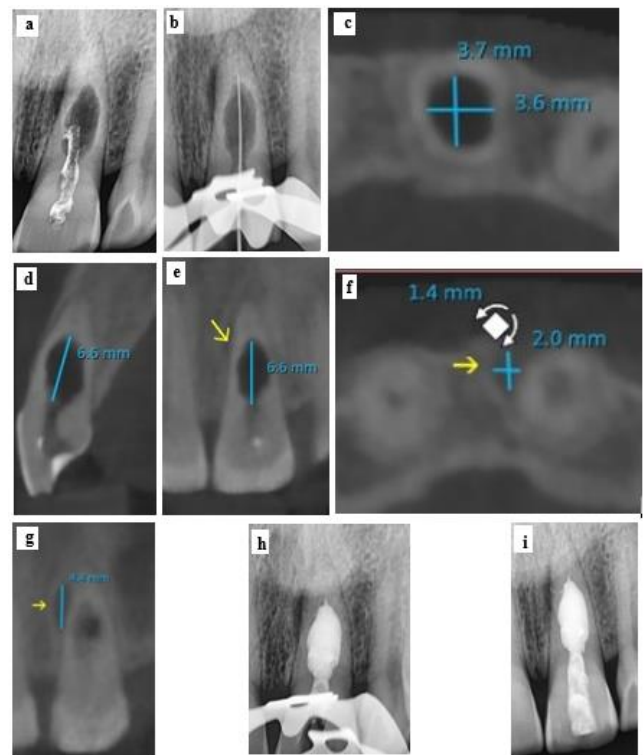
a: Pre-op x-ray; b: working length X-ray; c-g: CBCT images of the internal resorption and external radiolucency; h: thermoplasticized obturation; i: post-op X-ray.
